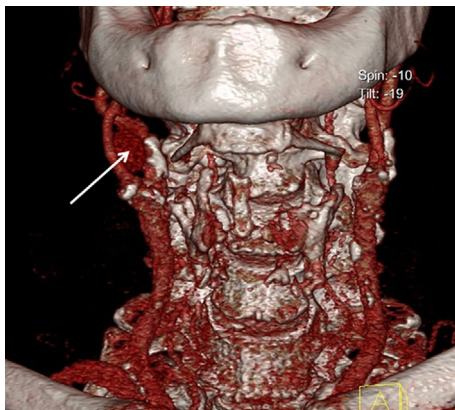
CT angiography of the neck vessels showing a carotid body tumor on the bifurcation of the right common carotid artery with mild compression of the right internal carotid artery (arrow).
